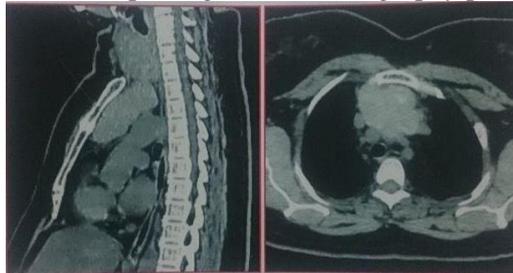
CT Neck and Chest Showcasing the Thyroid Gland Extending Behind the Sternum
